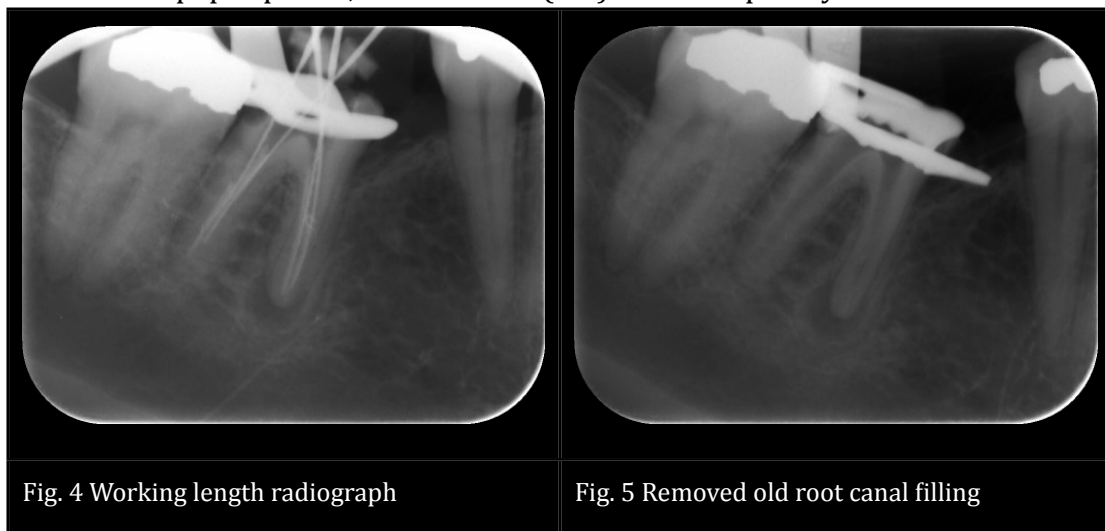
Working length radiograph
